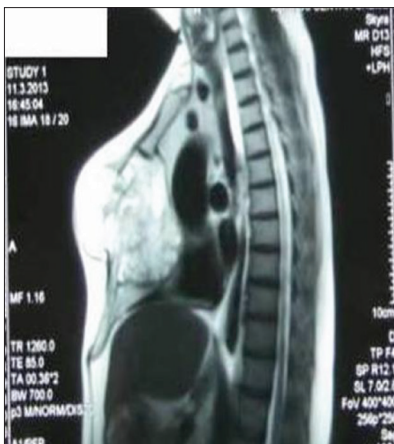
Preoperative chest magnetic resonance imaging scan (sagittal view)
